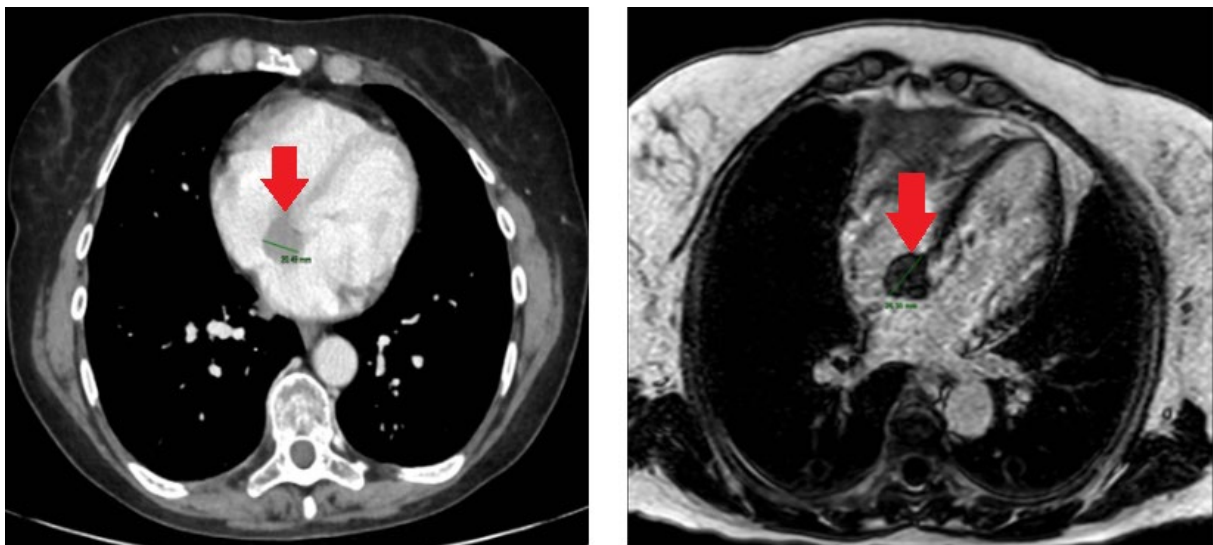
CT (left) and cardiac MRI (right) staging images. The lesion is indicated by red arrows.
